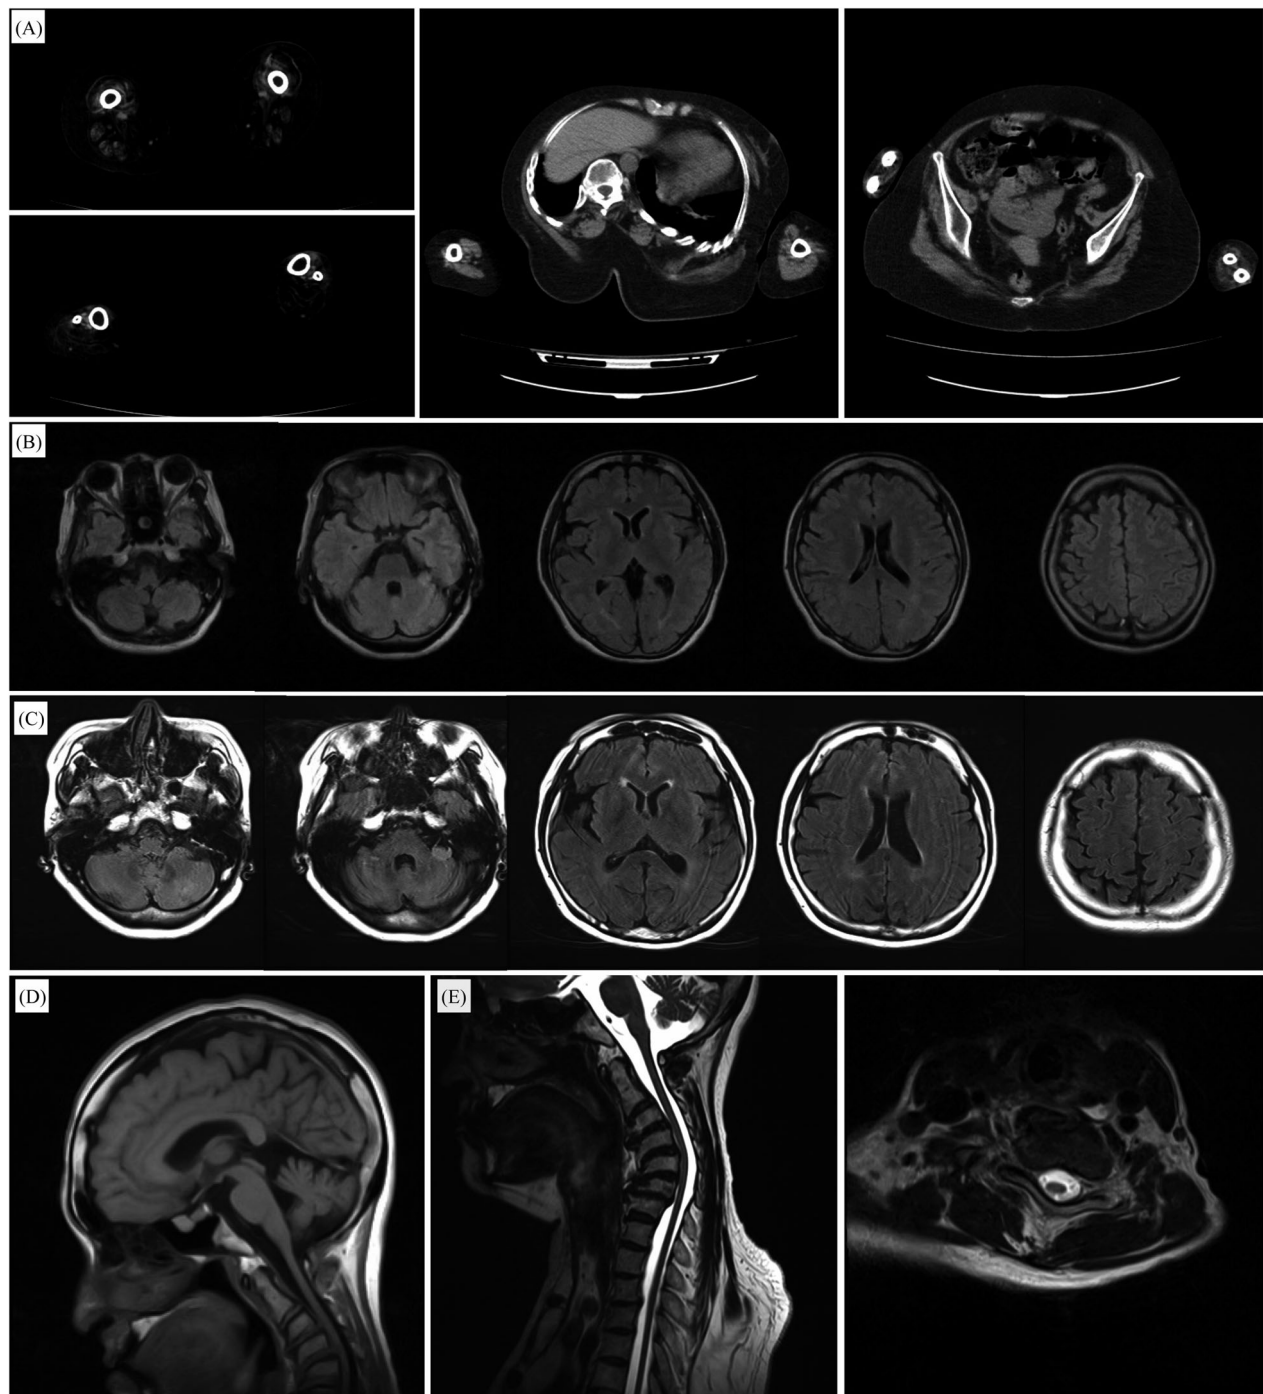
Radiological findings in patient 1 with *POLR3B* Arg469Cys. (A) Her computed tomography (CT) at age 51 shows marked muscle atrophy in both distal and proximal lower limbs, and in upper limbs with distal predominance. (B) Brain MRI axial slice at age 47, suggesting mild cerebellar atrophy and left cerebellopontine angle meningioma. (C) Brain MRI axial slice at age 53, with no notable changes in her cerebellar volume and meningioma. (D) Brain MRI sagittal slice at age 47, showing atrophy of cerebellar but not in corpus callosum. (E) Cervical spine MRI at age 50 showing cervical spinal cord atrophy.
